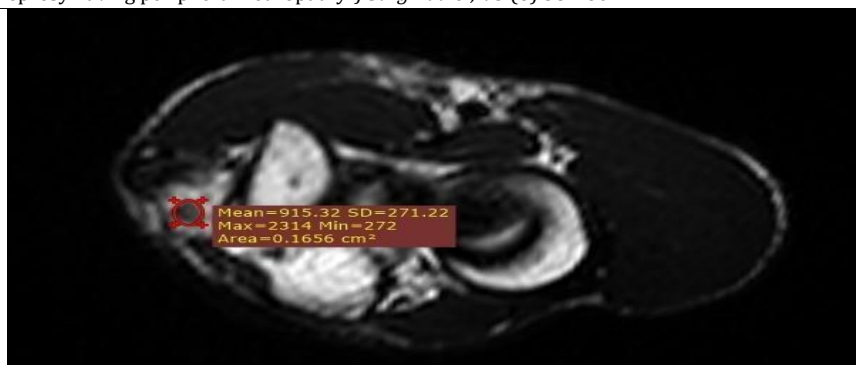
Axial T2-weighted MR image at the level of the right elbow demonstrating diffuse thickening of the ulnar nerve with mildly increased intraneural signal intensity and relative loss of the normal fascicular pattern (region-of-interest area 0.17 cm²).
